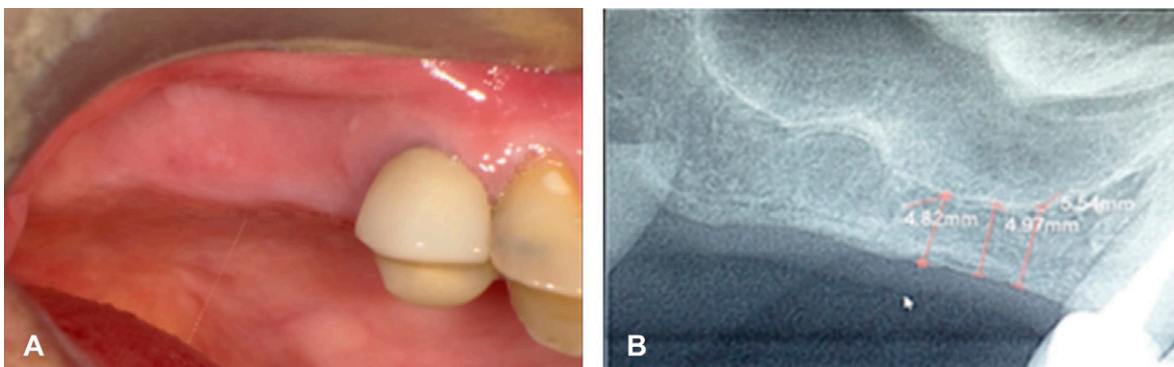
Initial photographs. A. Clinical photograph of healthy soft tissues. B. Digital radiography showing the low bone height with respect to the maxillary sinus floor.
